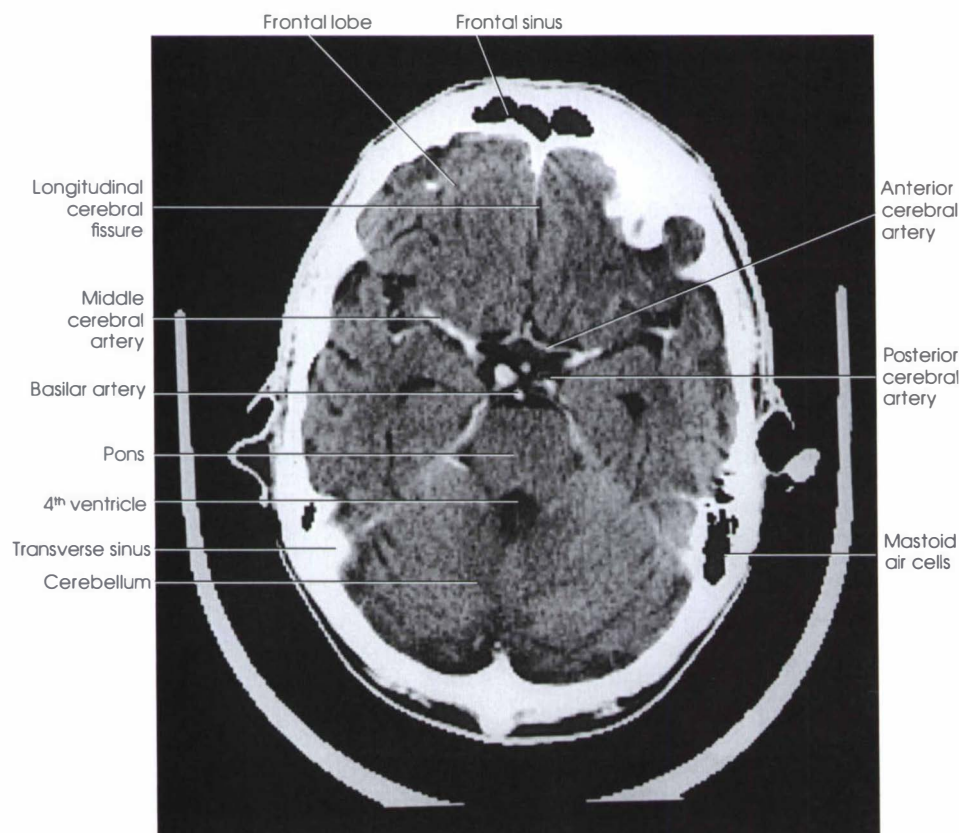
CT image representing the anatomic structures located at level C in Fig. 27-1.
